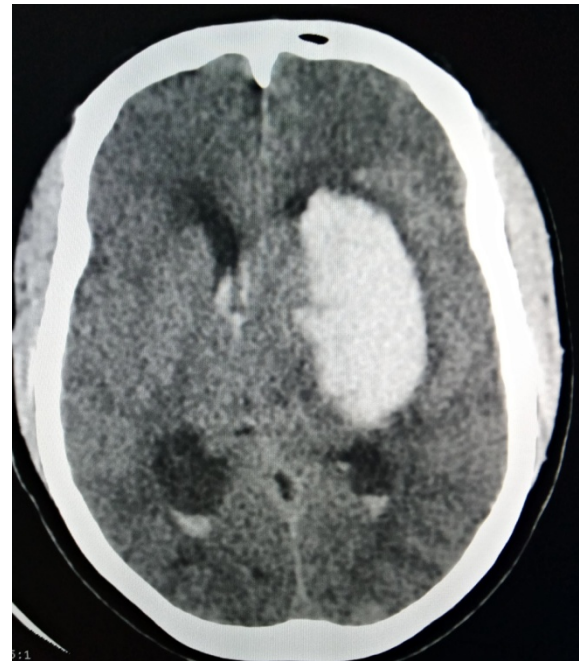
An axial CT brain image demonstrating cerebral haemorrhage
